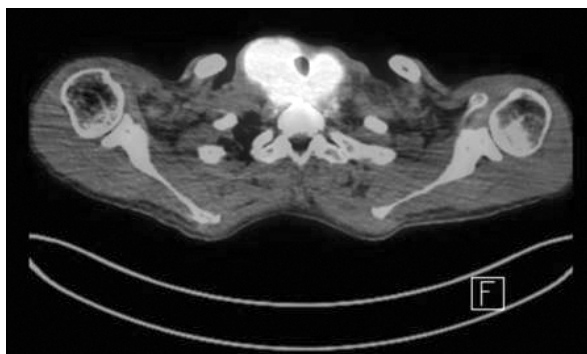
PET-CT scan 4 months after total thyroidectomy. PET-CT image showed a markedly increased hypermetabolic mass (SUV 43.9) in the neck.
